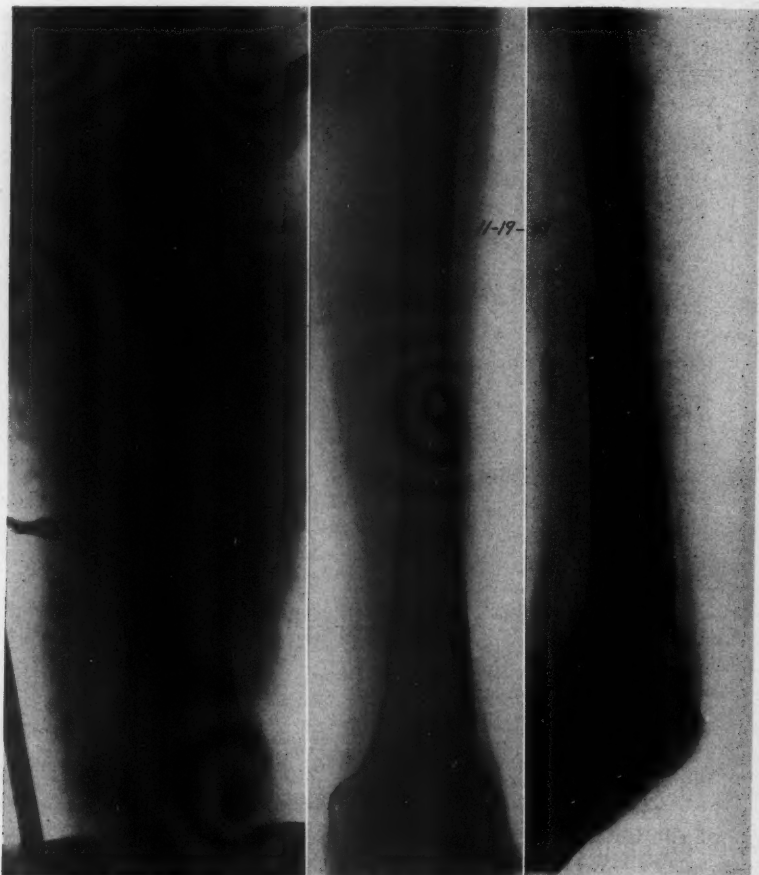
Shows a transverse fracture in the distal portion of the middle third of the femur which has been fixed by open reduction and internal fixation with a Kuntscher type of intramedullary nail. Weight-bearing was allowed at the end of 1 month; no external fixation was utilized at any time. Patient was back at full activity at the end of 3 months. Follow-up roentgenograms made at 7 months after injury shows solid bony union in proper alignment and position with the nail remaining in place.
